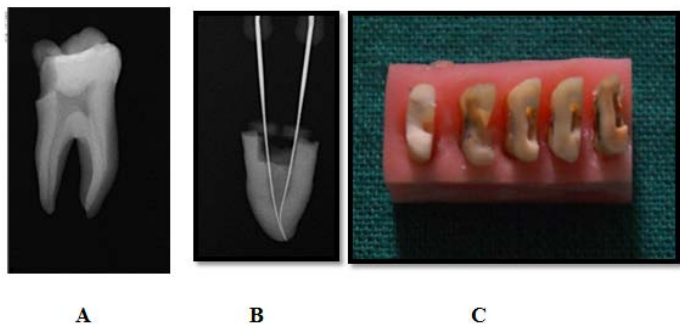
(A) Pre Operative Radiograph of Samples (B) Working Length Radiograph of Samples (C) Samples mounted on acrylic block.
